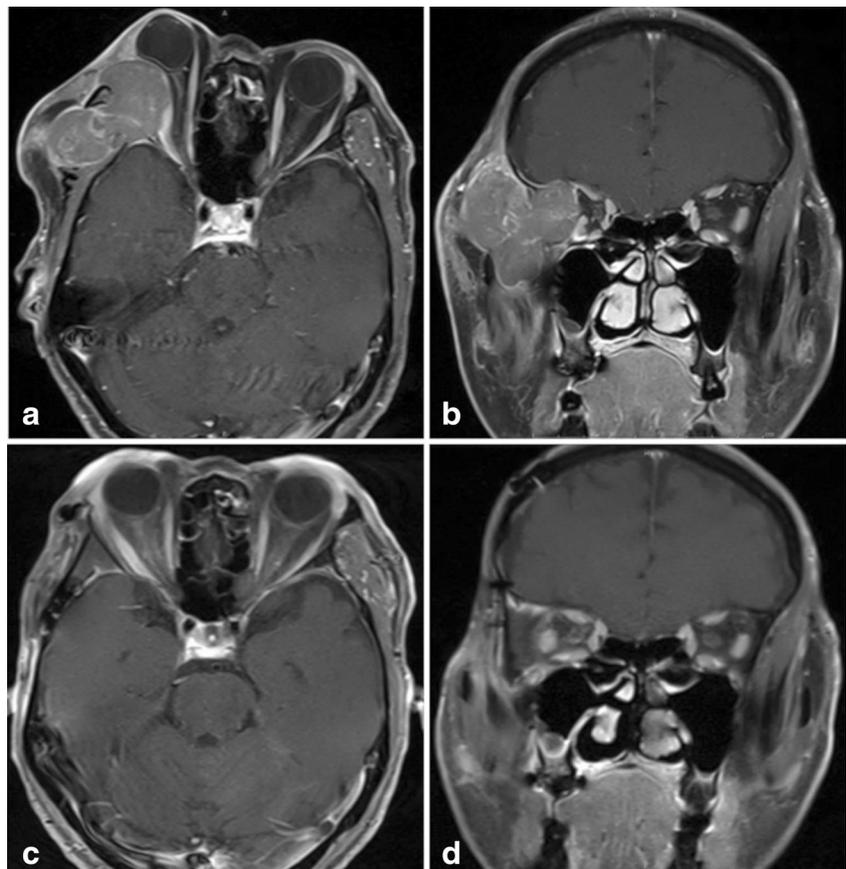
Magnetic resonance imaging (MRI) of right orbital wall mass, pre- and post-intervention. a, b axial and coronal T1-weighted MRI images of the right orbital mass lesion shown via biopsy to be metastatic hepatocellular carcinoma (HCC). Note mass effect upon right eye structures, including the optic nerve and globe, without invasion into these structures. c, d Equivalent T1 axial and coronal views show the right orbit after successful metastasis radioembolization followed by resection with skull reconstruction
